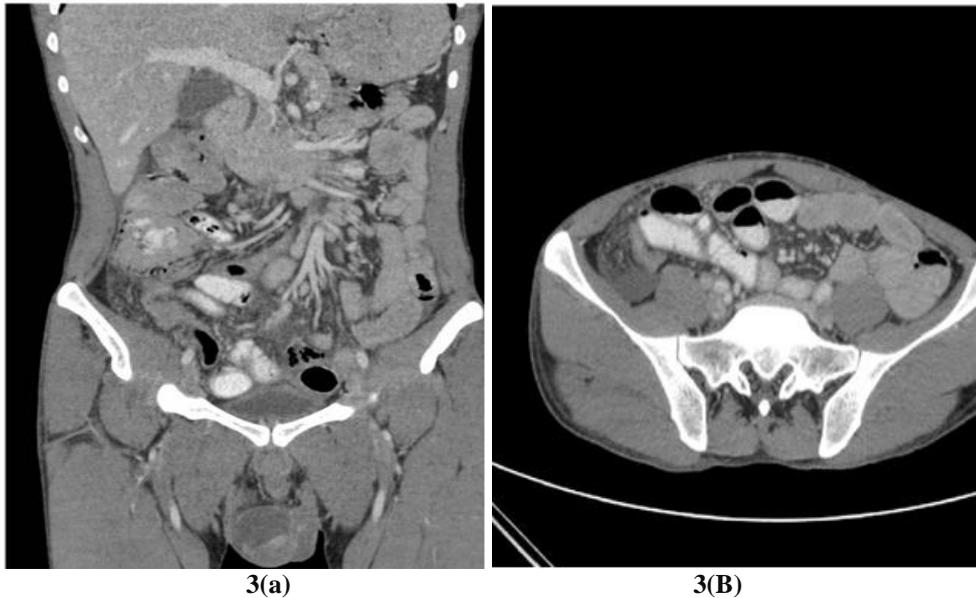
(a) 3(B): Coronal and axial contrast CT Images of patient reveal evidence of extraluminal free air in pelvis with thickening and enhancement of peritoneum in right lower abdomen consistent with peritonitis.
